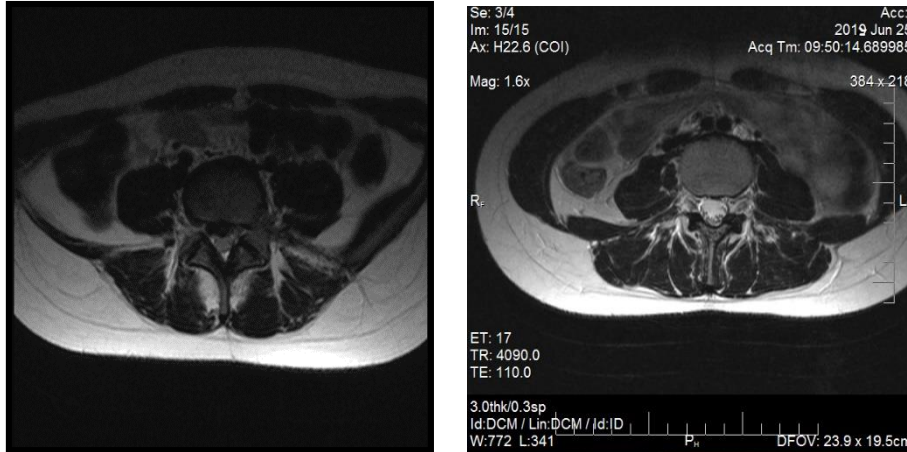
Lumbar spine MRI before and after rehabilitation program
